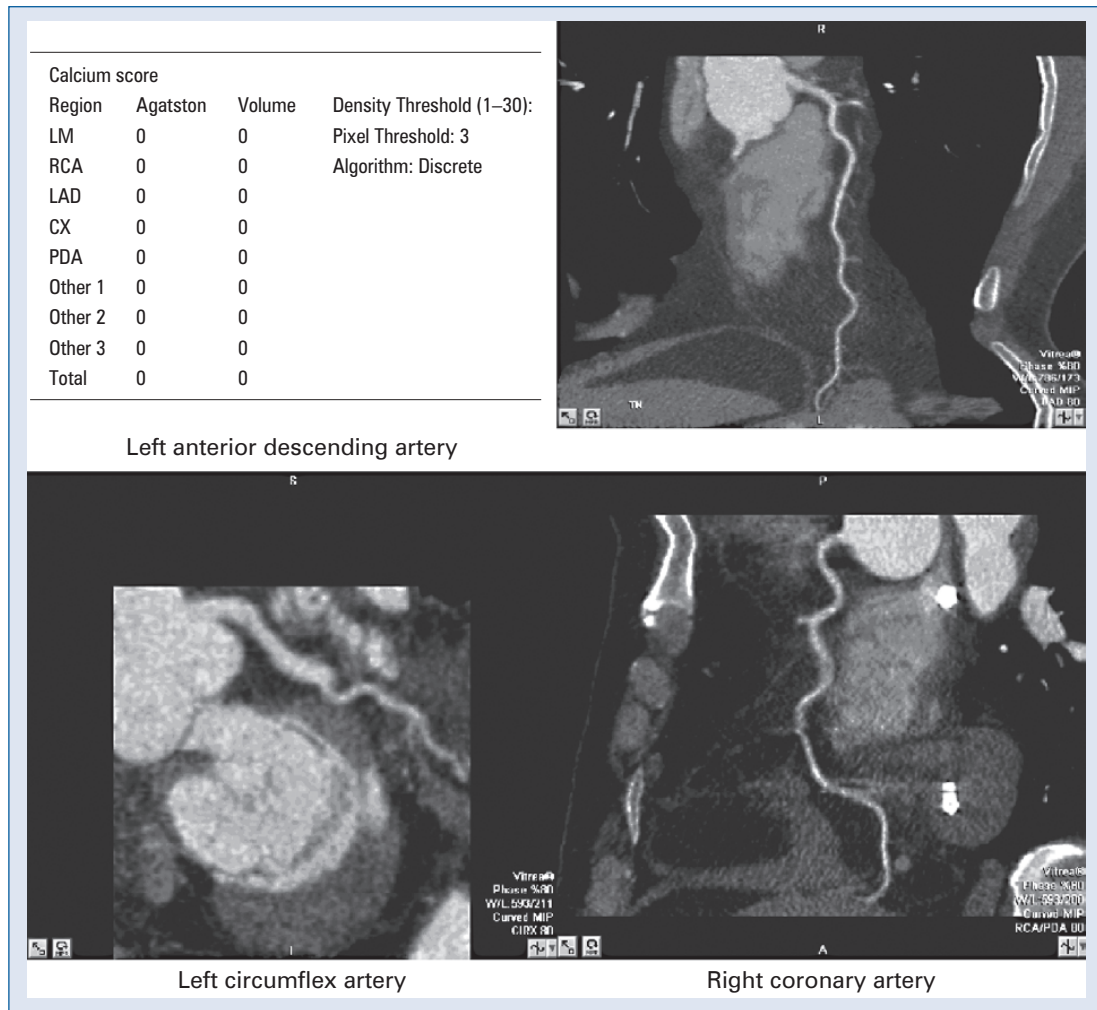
B. A 57 year-old patient with diabetes on hemodialysis; equivocal stress echocardiography referred for coronary angiography. Research CCTA shows zero calcium score and no significant coronary disease and interpretable scan.
